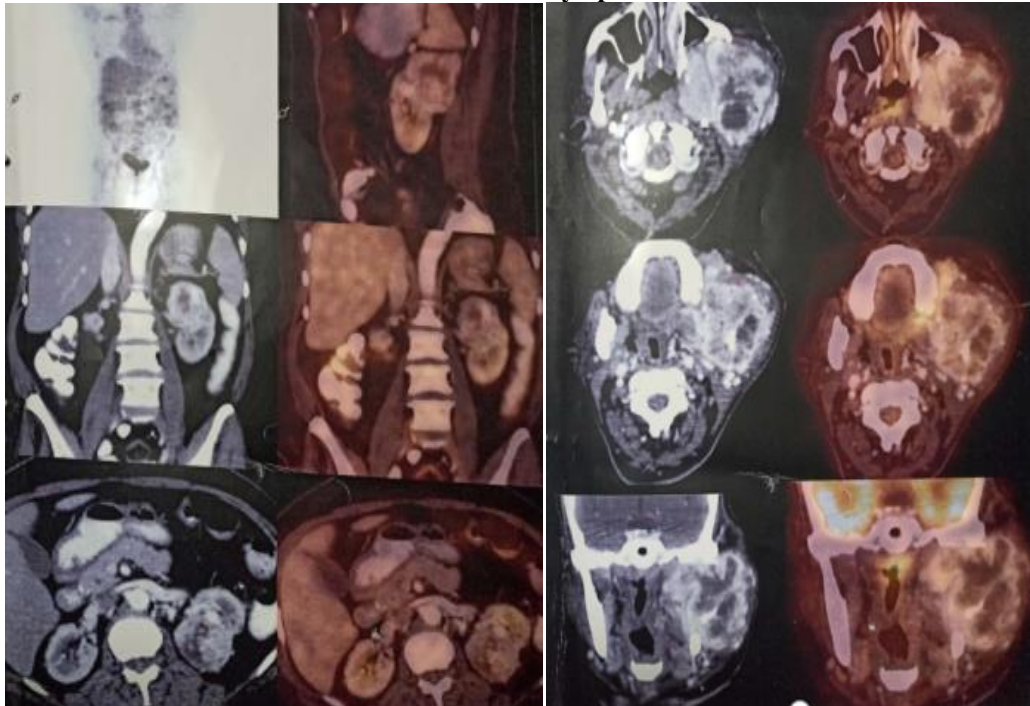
2-PET CT reveals metabolic active mass lesion in upper lobe of left kidney, ?primary renal malignancy. Metabolic active soft tissue density lesion at post op bed, suggestive of residual disease. FDG active / non active lymph node.
